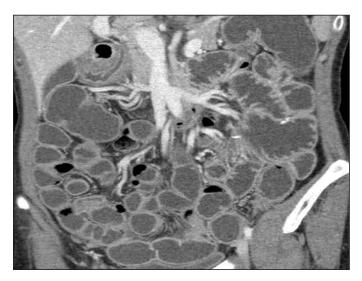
Normal CT enteroclysis showing good distention of small bowel loops in coronal reformation. Normal enhancement of bowel and mesenteric vessels are seen.
